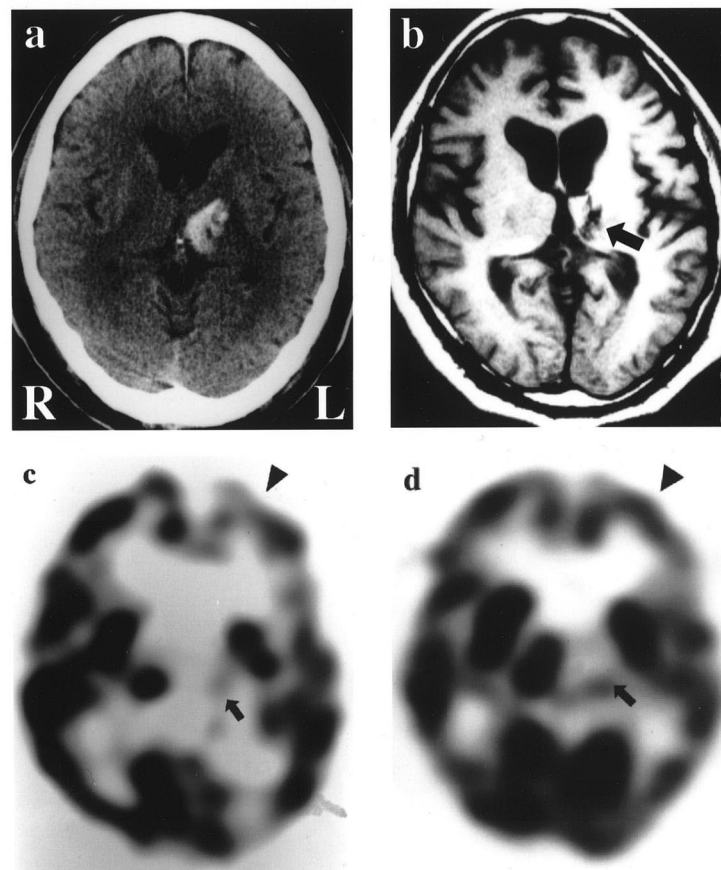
(a) Plain CT 5 h after onset showing high density area in the left thalamus. (b) T1 weighted axial MR image 6 months after onset showing a hypointensity in the left thalamus (arrow). (c) SPECT image with ^{123}I -IMP showing a complete perfusion defect in the left thalamus (arrow) with a slight reduction of perfusion in the left frontal lobe (arrowhead). (d) SPECT image 15 months after onset showing an improvement of the hypoperfusion in the left frontal lobe (arrowhead), but not in the thalamus (arrow).
